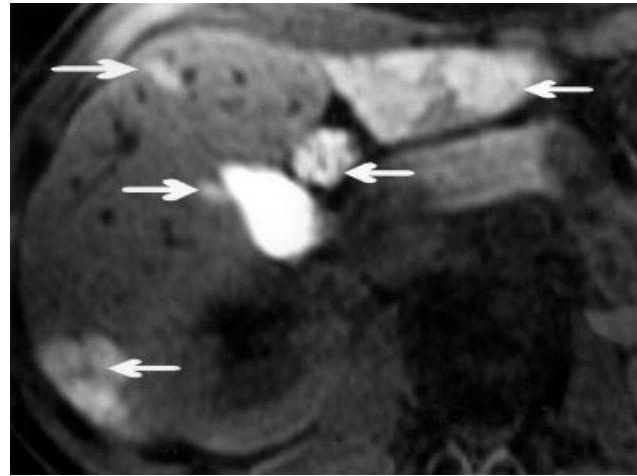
Teslascan MRI at 24 hours after injection: uptake of contrast in left lobe and lateral aspect of right lobe by multiple adenomas (arrows).
